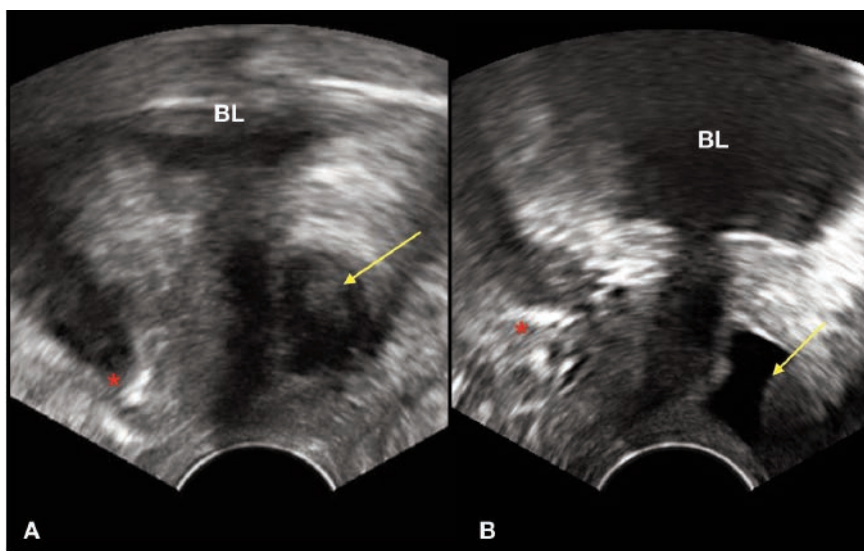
Trans-labial ultrasound of a simple (A) and complex (B) urethral diverticulum in longitudinal section (BL: bladder; yellow arrow: urethral diverticulum; red star: pubis)
